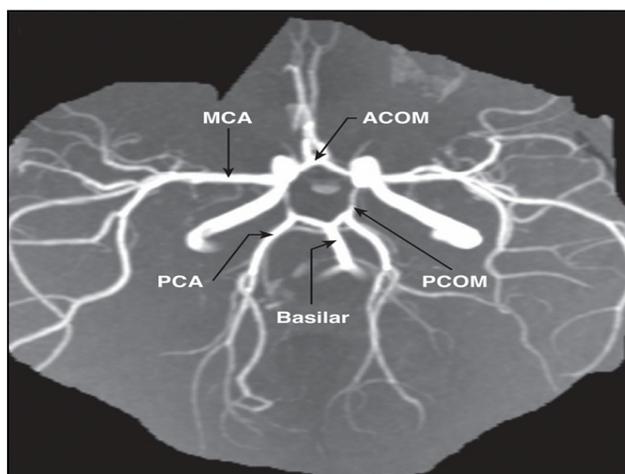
Magnetic Resonance Imaging Arteriography showing Arterial circle of Willis (MCA: Middle cerebral artery ;PCA: Posterior cerebral artery; ACOM: Anterior communicating ;PCOM: Posterior communicating branch; Basilar artery).
